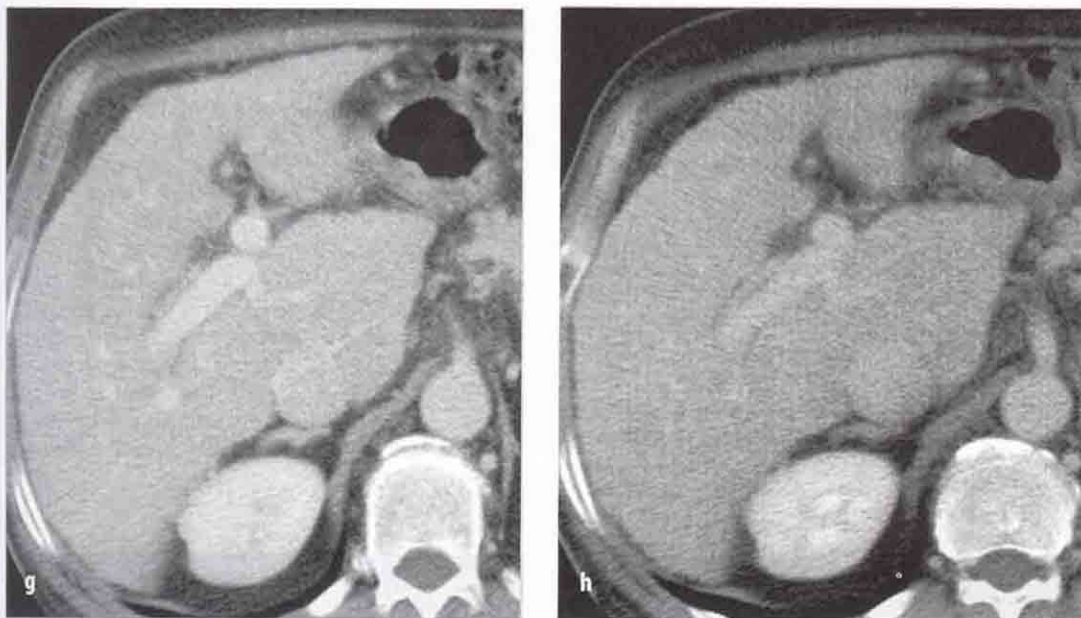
Hepatocellular carcinoma. At baseline US examination the lesion appears as an iso-hypoechoic nodule (a). At contrast-enhanced US, the lesion shows early enhancement in the arterial phase (b) with rapid wash-out in the portal-venous and delayed phases (c, d). At multidetector CT (e, baseline; f, arterial phase; g, portal-venous phase; h, delayed phase) the same enhancement pattern is observed
